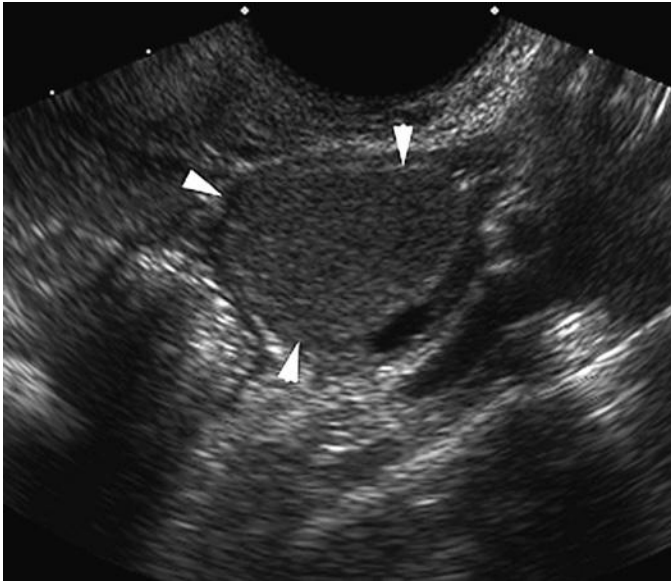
Endometrioma. Coronal gray-scale transvaginal sonographic image of the left ovary demonstrates a complex cyst (*arrowheads*), containing diffuse homogeneous low-level internal echoes, consistent with an endometrioma.
